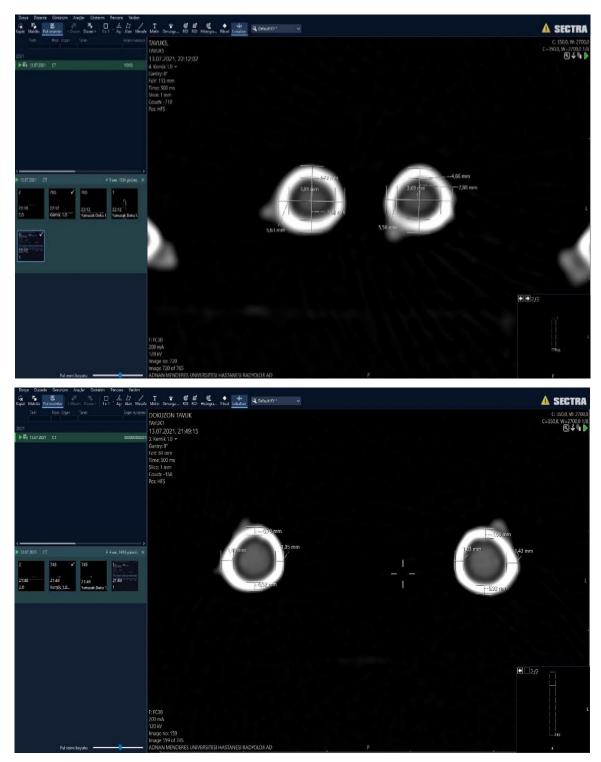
PACS system showing CT scanned images for measurement.
